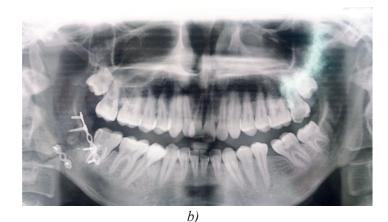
3. Screw fixation using a trocar and cannula through a trnasbuccal puncture incision. *a) Intraoperative image. b) Orthopantomogram after surgery*
